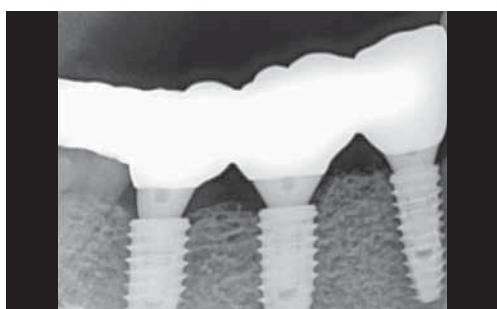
Periapical radiograph after delivery of the final prosthesis.
